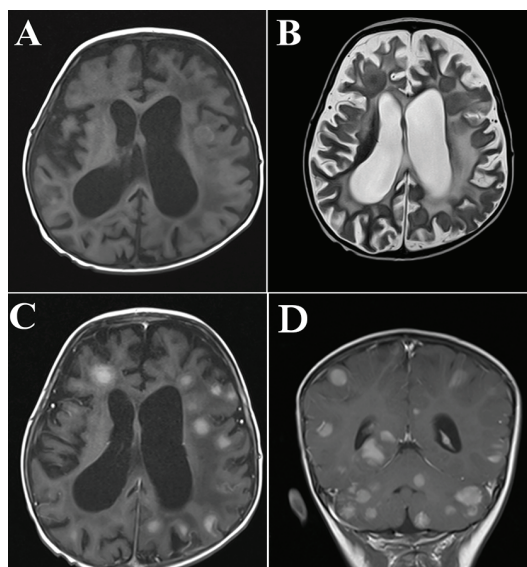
Brain MRI demonstrated peripheral hyperintense, central isointense lesions on T1-weighted MRI images (A) and peripheral hypointense, central hyperintense lesions on T2-weighted MRI images (B) with surrounding vasogenic edema in the white matter. Lesions showed well-contrast enhancement on axial (C) and coronal images (D) following intravenous contrast media administration
